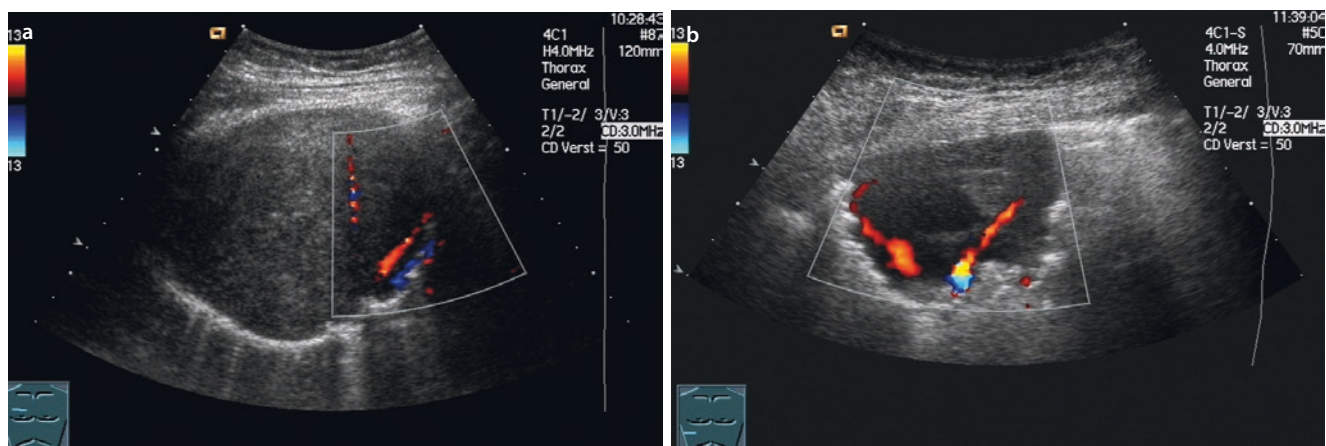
a Large tumor in the upper lobe of the right lung, displacing the artery and vein of the upper lobe in medial direction. Sonographic biopsy indicated poorly differentiated neuroendocrine
